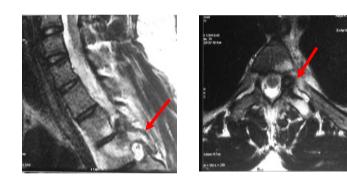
MRI showing lesion with surrounding edema in left pedicle of T3 vertebra.
